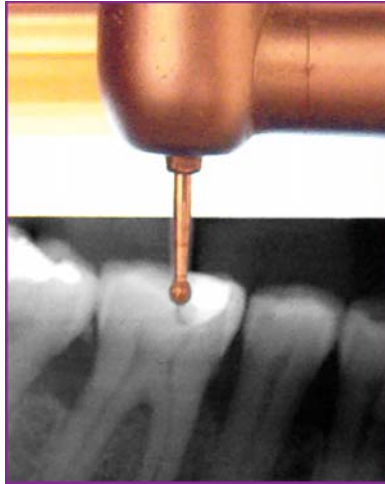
Bur placed close to the pretreatment radiograph to estimate approximate depth of the roof of the pulp chamber or the furcation of the tooth
